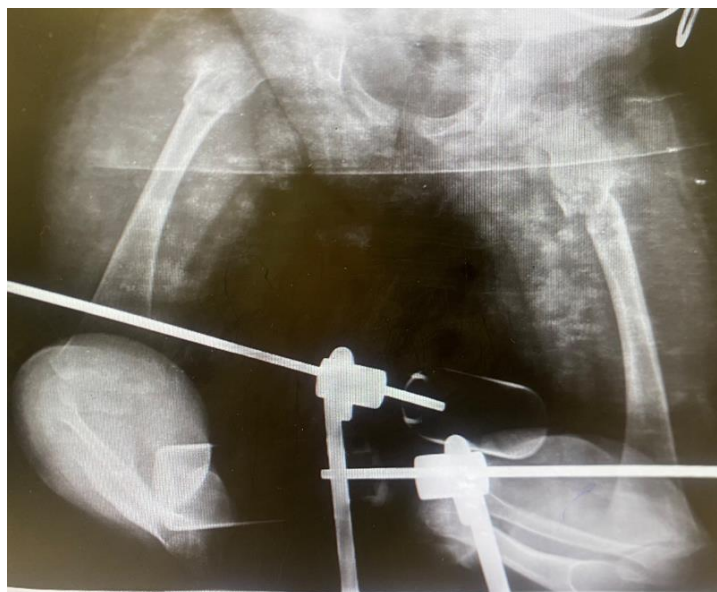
Post-treatment radiograph after placing bilateral distal femoral pin. (Prepared by Authors, 2026).
